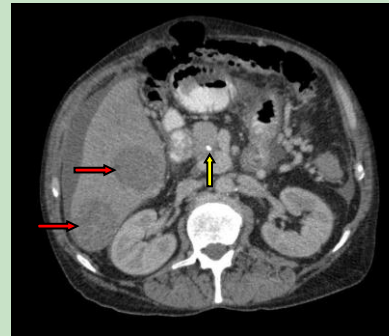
A CT scan abdomen with contrast showing hepatic (red arrows) and pancreatic (yellow arrow) abscesses.
